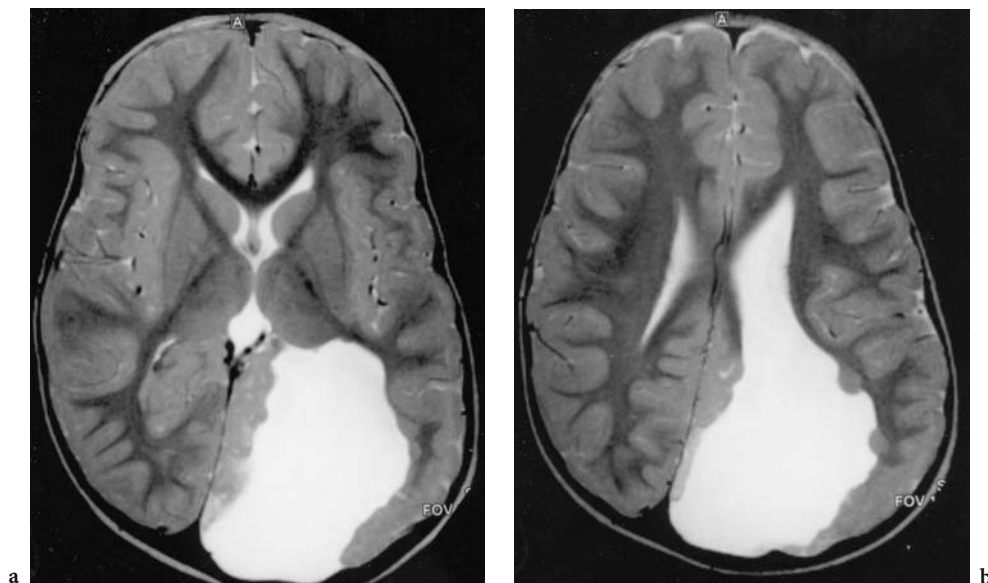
Axial T2-weighted FSE MRI of a 3-year-old boy with delay in motor and speech development and macrocephaly. MRI reveals large occipital parenchymal defect with several nodular heterotopias. No obvious visual field defects detectable, but final evaluation not yet possible at this age. Seizures occurred at 6 years of age
